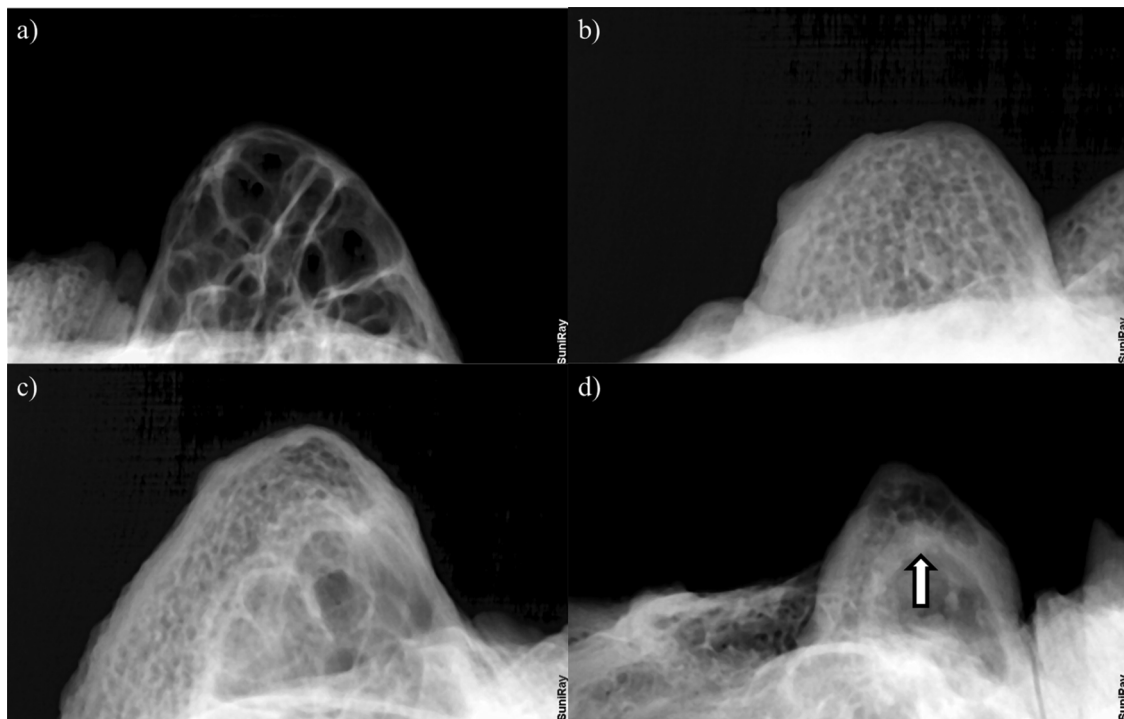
Radiographs of a) a healthy, fully pneumatized mastoid process, b) a hypocellular mastoid process, c) a partially pneumatized mastoid process, and d) a mastoid process with an abnormally large void and sclerotic sub-endosteal bone growth (indicated by arrow) (Hodgson, 1938; Radiopaedia, 2019a,b).
